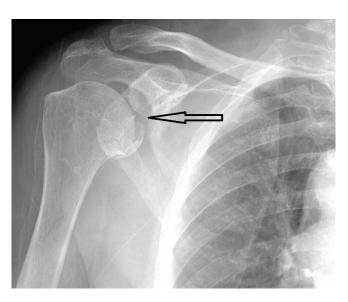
Shoulder radiograph: black arrow points to suspected fracture of glenoid rim.
